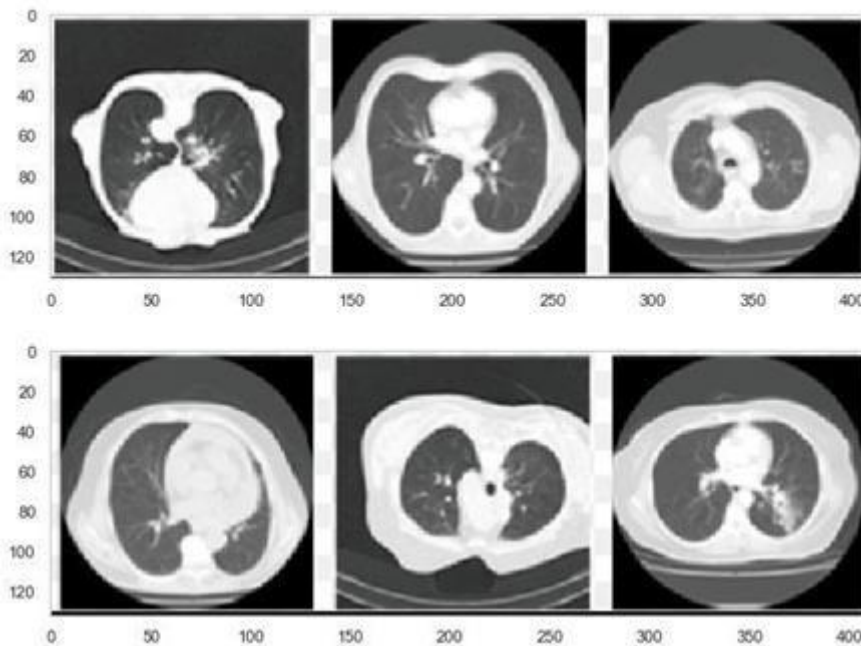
Sample Lung CT Images
